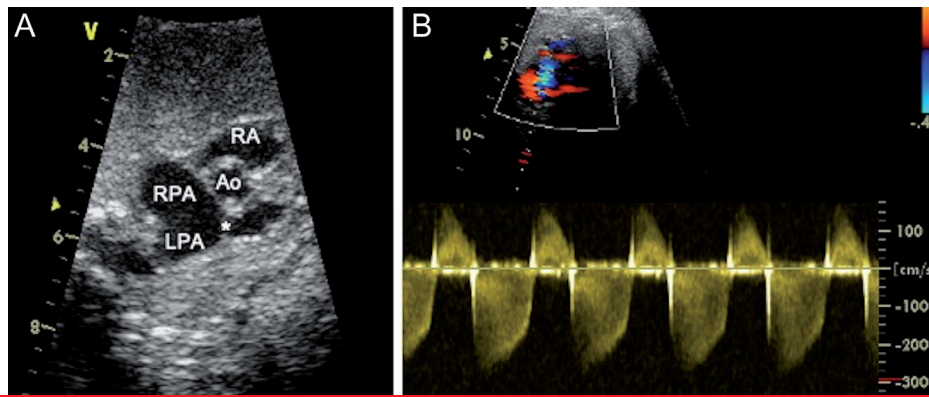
(A) Typical echocardiographic image of fetus with TOF-APVS and dilated pulmonary artery branches; (B) Pulmonary flow by pulsed-wave Doppler showing pulmonary stenosis and regurgitation. TOF, tetralogy of Fallot; APVS, absent pulmonary valve syndrome; RA, right atrium; Ao, aorta; RPA, right pulmonary artery; LPA, left pulmonary artery. *Pulmonary fibrous annulus.
